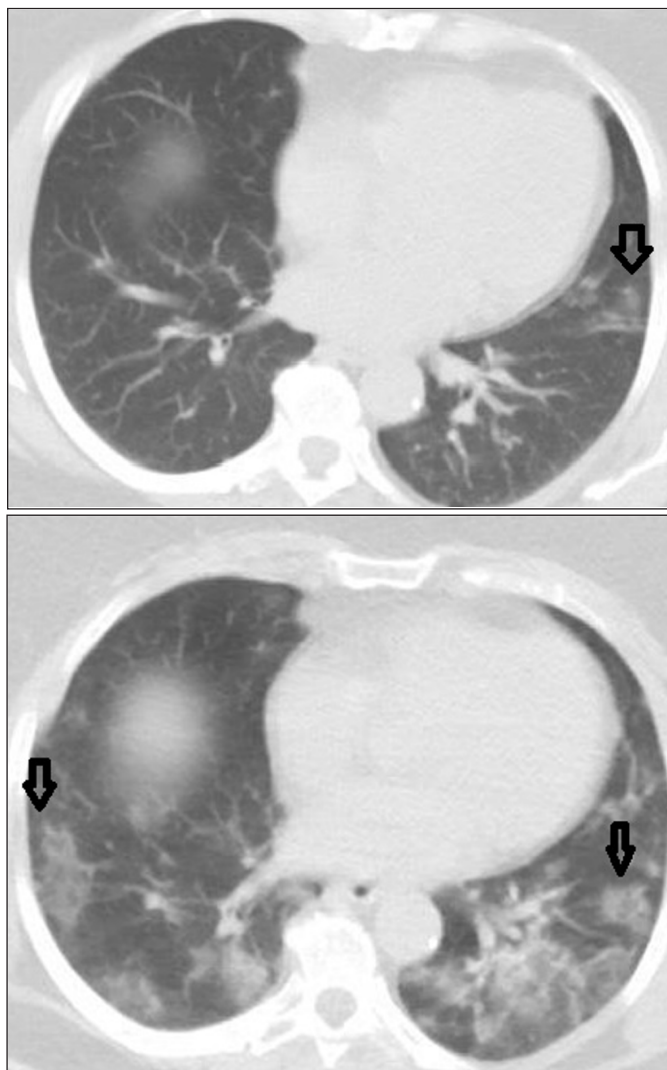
a. Chest CT image of a 61-year-old woman, who was infected with Wuhan Type COVID-19 virus in April 2020, shows patchy GGO only in the inferior lingular segment. b. Same patient was infected with B.1.1.7 variant in April 2021 again and her CT image shows widespread GGO in both lung, distributed in the subpleural and central areas
